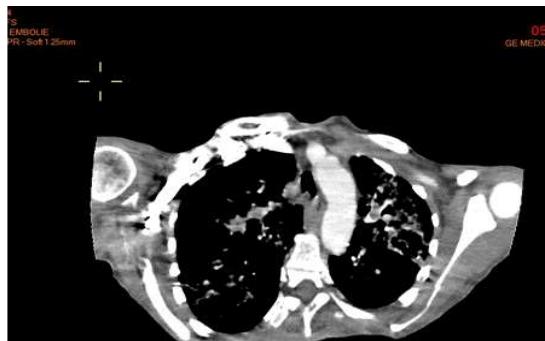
CT image in favor of right upper lobar segmental bronchial pulmonary embolism.
